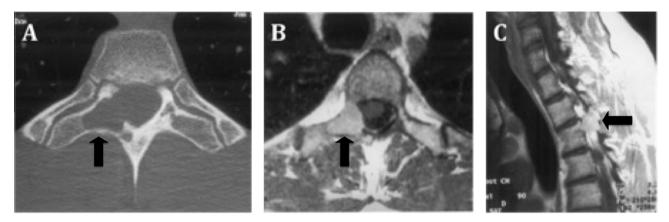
(A) Axial CT scan demonstrating erosion of the right T3 pedicle, hemilamina (black arrow), and transverse process. (B) Axial contrast enhanced T1-weighted MRI revealing a uniformly enhancing lesion (black arrow) involving the right T3 pedicle, hemilamina, and transverse process. (C) Sagittal contrast enhanced T1-weighted MRI revealing a uniformly enhancing lesion at the T3 level (black arrow).
